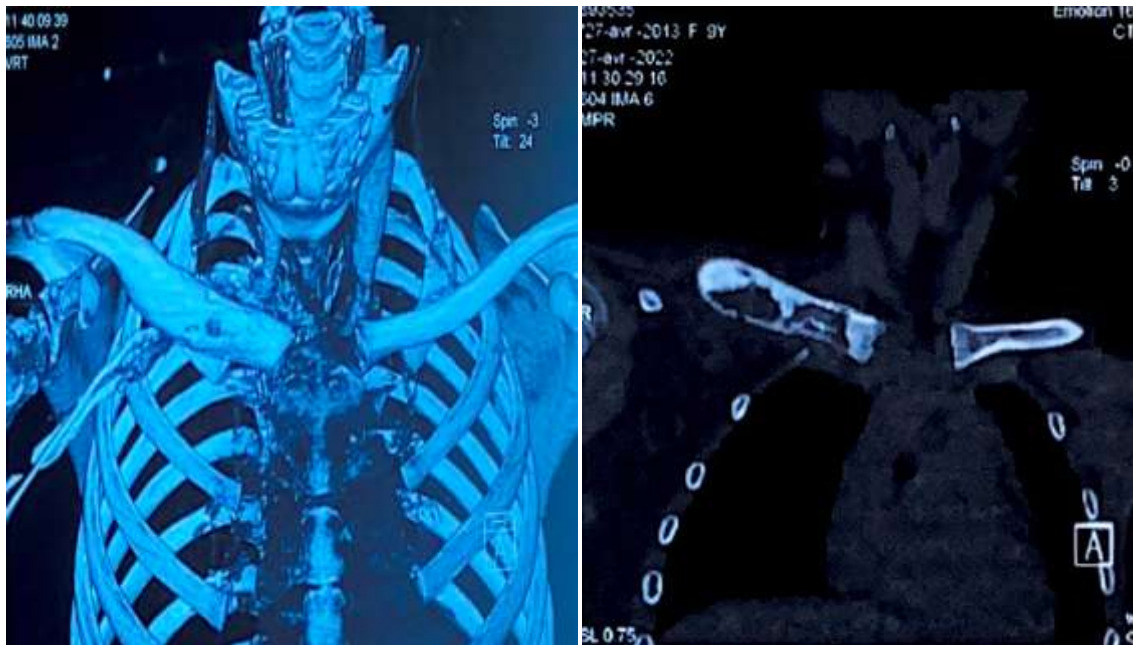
CT images of the bone tumor located of the right clavicle.
